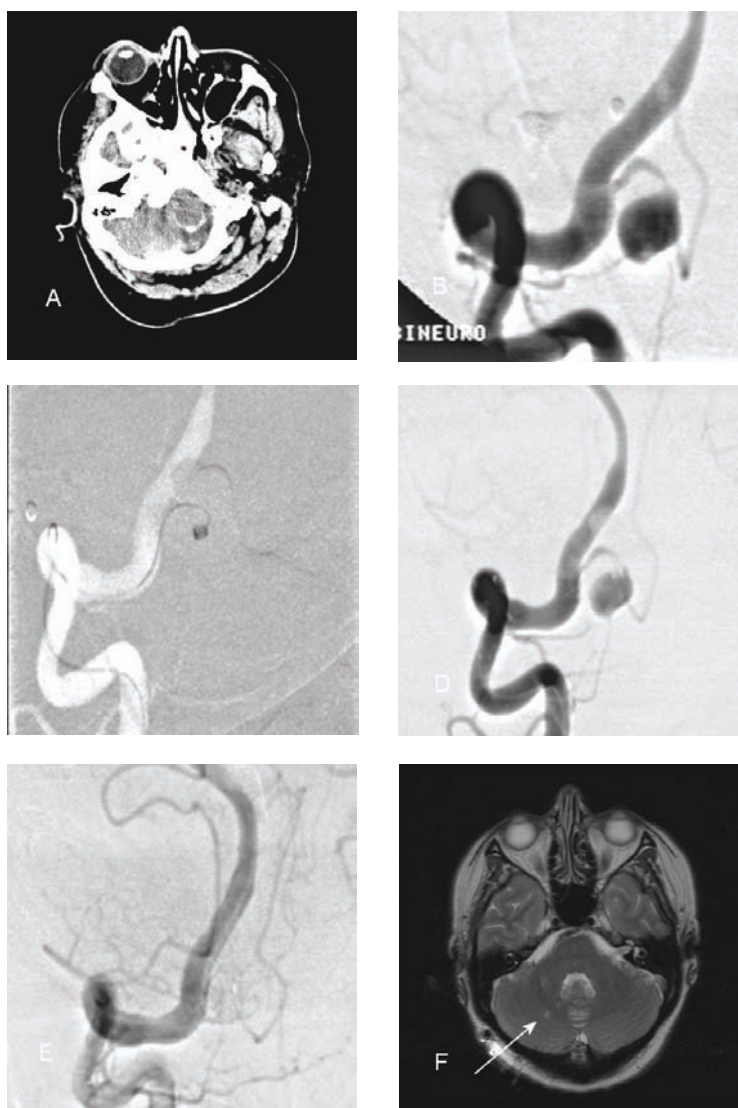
Case 346. A 55-year-old female experienced acute headache, and CT scan revealed basal SAH with blood accumulation around the brain stem (A). Initial angiography was negative. The patient recovered and was discharged without follow-up angiography. Three weeks later she had recurrent bleeding, and repeat angiography revealed a dissecting aneurysm in left PICA (B). The aneurysm was treated by occluding the proximal PICA with one coil (GDC-10 2mm x 6cm SOFT) anchored to the aneurysm neck and the PICA origin in VA (C). Angiography immediately after the procedure showed residual flow in proximal PICA and aneurysm filling (D). Follow-up angiography revealed complete occlusion of proximal PICA and a dissecting aneurysm, while distal PICA was filling retrogradely by collateral flow from ipsilateral SCA (E). Postprocedural MRI revealed a small lacunar cerebellar infarct (arrow) without any clinical consequences (F).
